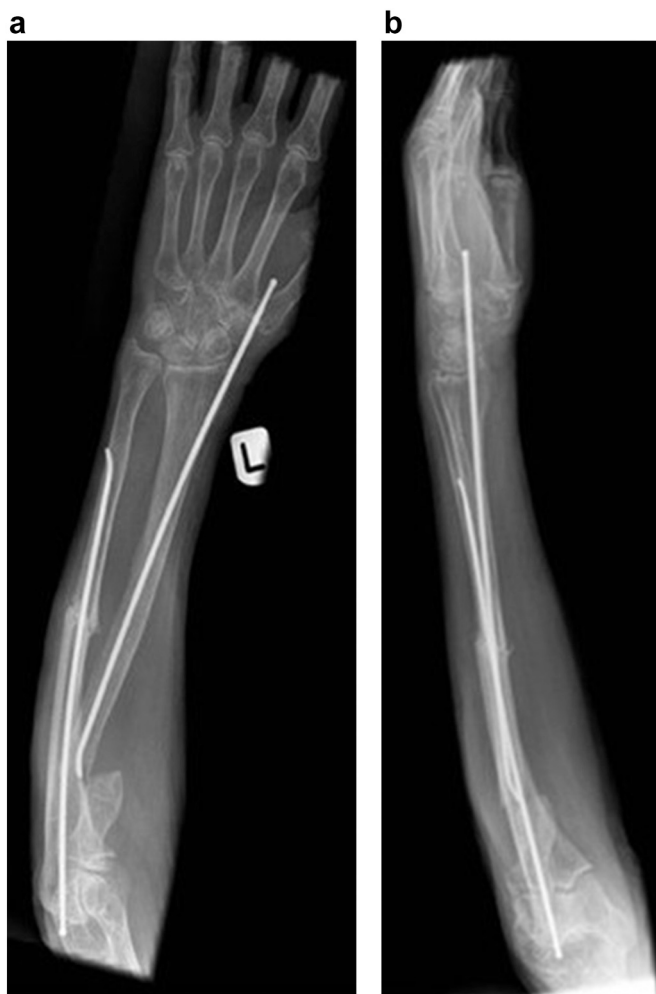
A–B: AP and lateral radiographs showing failed treatment with Nancy nails.
